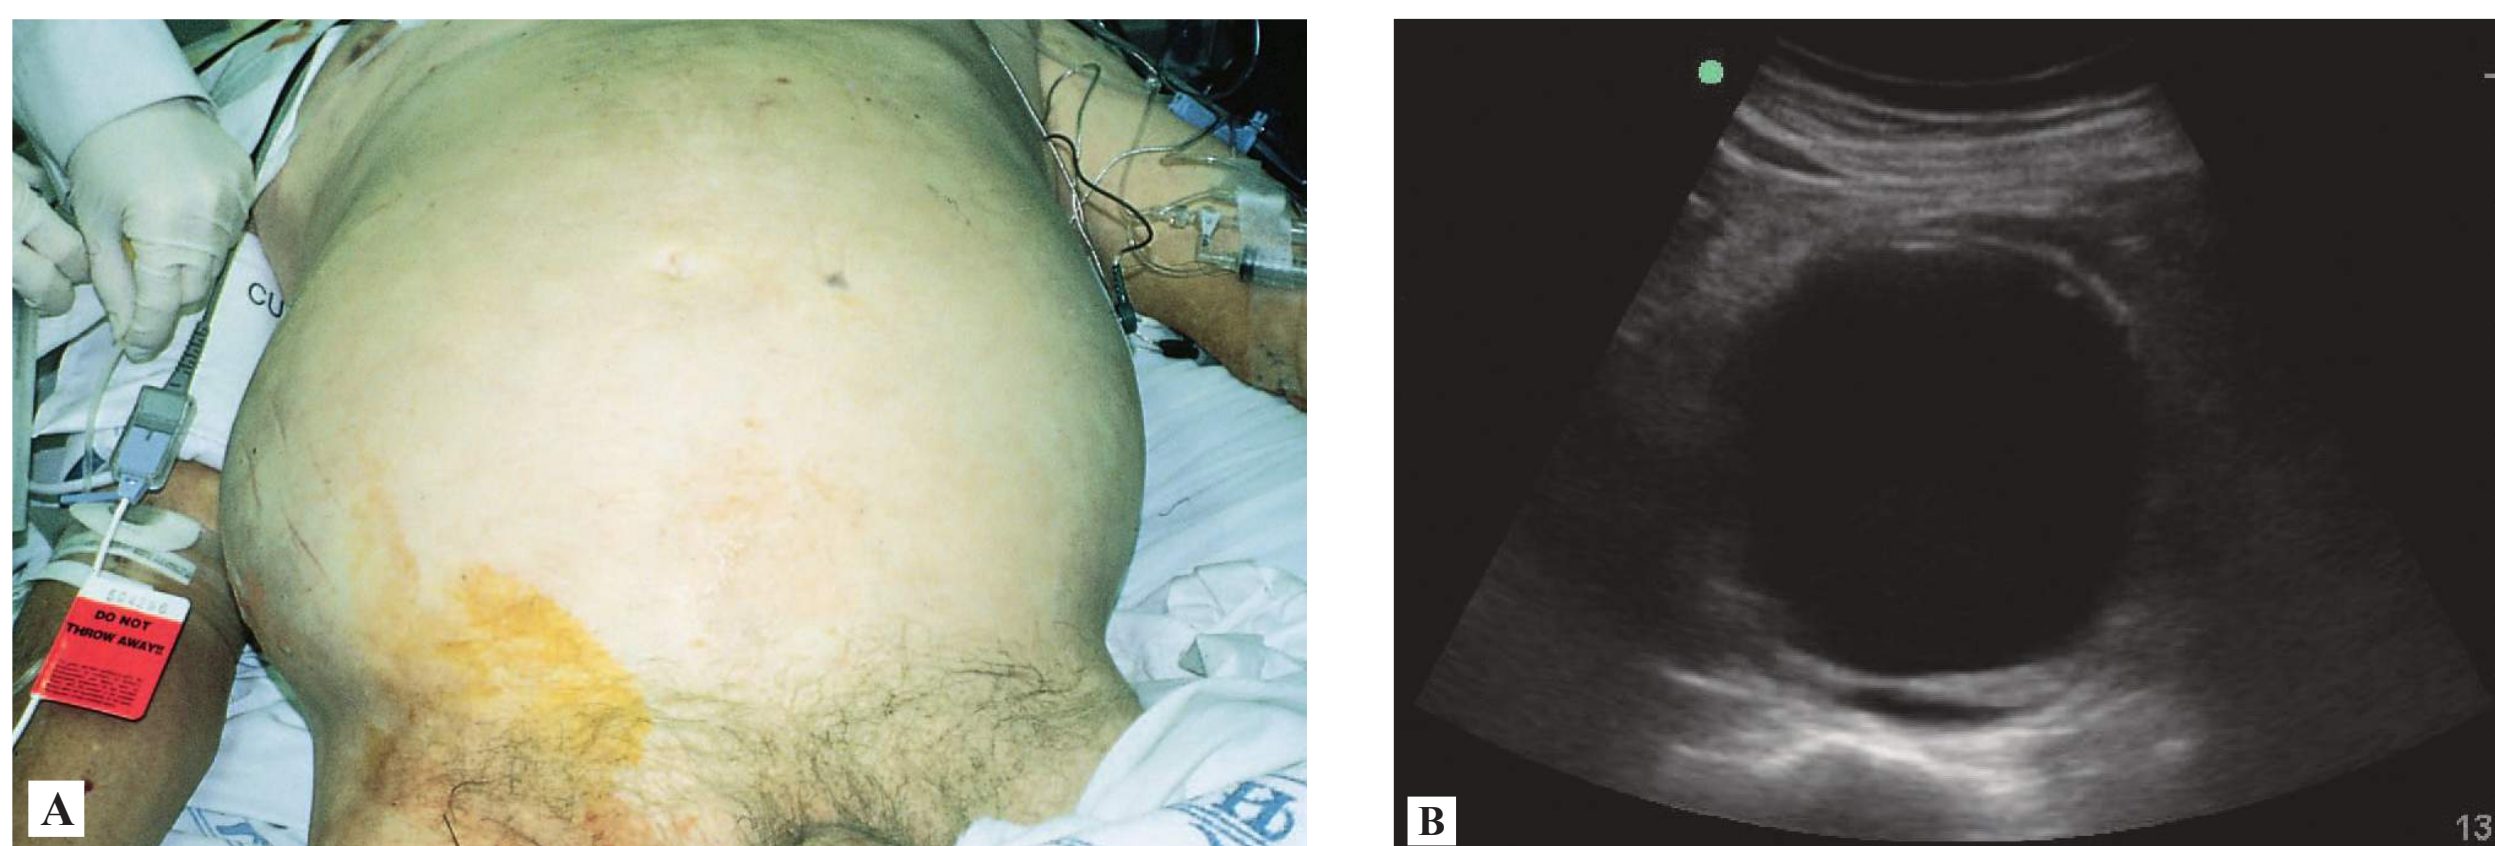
■ Abdominal Aortic Aneurysm. (A) The abdomen of a patient with a leaking abdominal aortic aneurysm. Note the mottled abdominal wall and the prominent curvature of the right side of the abdomen. (Photo contributor: Stephen W. Corbett, MD.) (B) Eight-centimeter abdominal aortic aneurysm seen in cross-section on an ultrasound in different patient. (Photo contributor: Jeremy Simpson Boyd, MD.)
